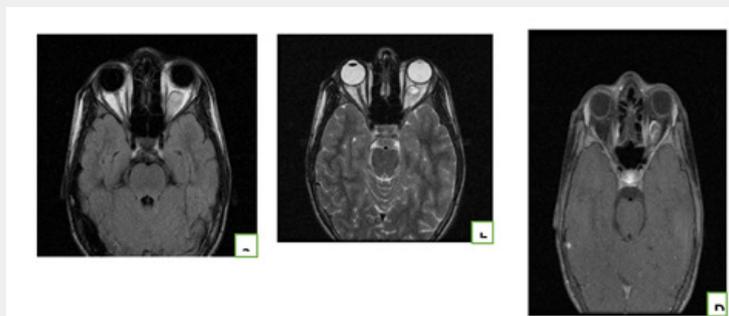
cerebral MRI in axial cut FLAIR (a), axial T2 (b), coronal T2 (c) and injected axial (b) showing an intra-conical, intra-orbital tissue process centered on the optic nerve that enhances in a heterogeneous manner in relation to an optic nerve glioma.
